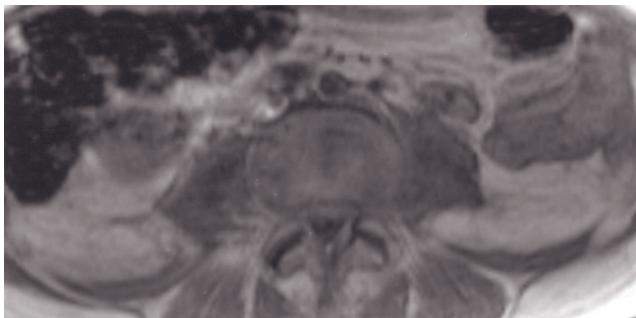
Psoas abscess. T2-weighted SS-ETSE (a), 45-s postgadolinium SGE (b), and transverse (c) and coronal (d) interstitial-phase gadolinium-enhanced fat-suppressed SGE images. A complex fluid collection is present in an enlarged left psoas muscle. The fluid is heterogeneously high in signal intensity on the T2-weighted image (arrow, a) and contains low-signal-intensity necrotic debris. The left ureter (large arrow, a) is dilated and has a thick wall. The abscess wall (arrow, b) and the ureteral wall demonstrate
